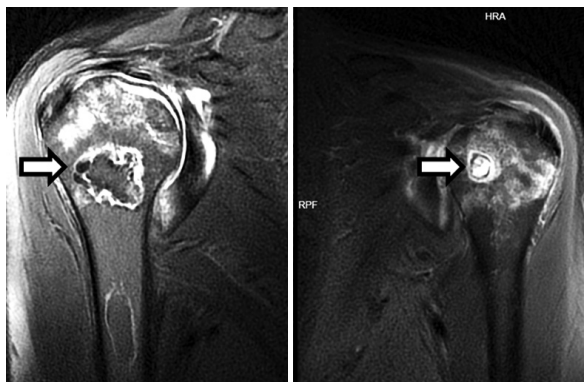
MRI revealing multiple areas of humeral head avascular necrosis (marked with white arrows)
